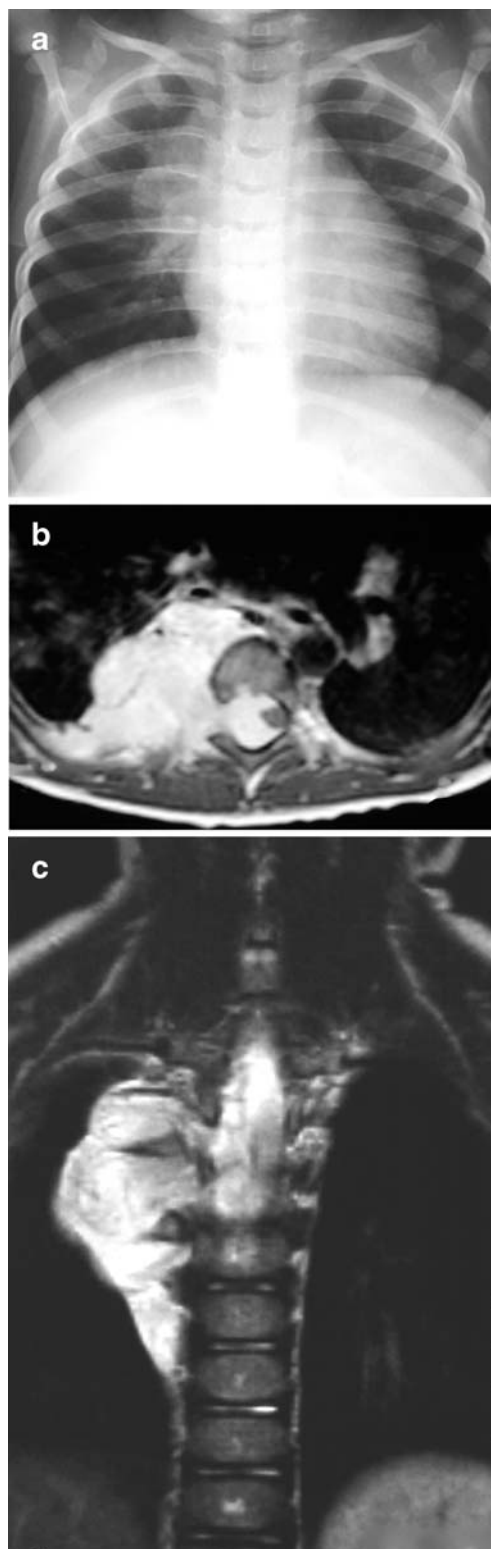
Neuroblastoma; posterior mediastinal mass involving the chest wall in a 3-year-old boy with posterior chest pain. (a) AP chest radiograph shows a dense paravertebral lesion. The fourth and fifth posterior ribs are thinner and the intercostal spaces are wider in this area. The well-defined borders of the elongated mass associated with the bone lesion, confirms the findings of an extrapleural lesion. Axial (b) and coronal (c) T2-W MR images show a mass located in the posterior mediastinum invading the extradural canal, several foramina and the posterior soft tissue in the right side. MR imaging is the best technique for the study of neurogenic tumours with invasion of adjacent structures
